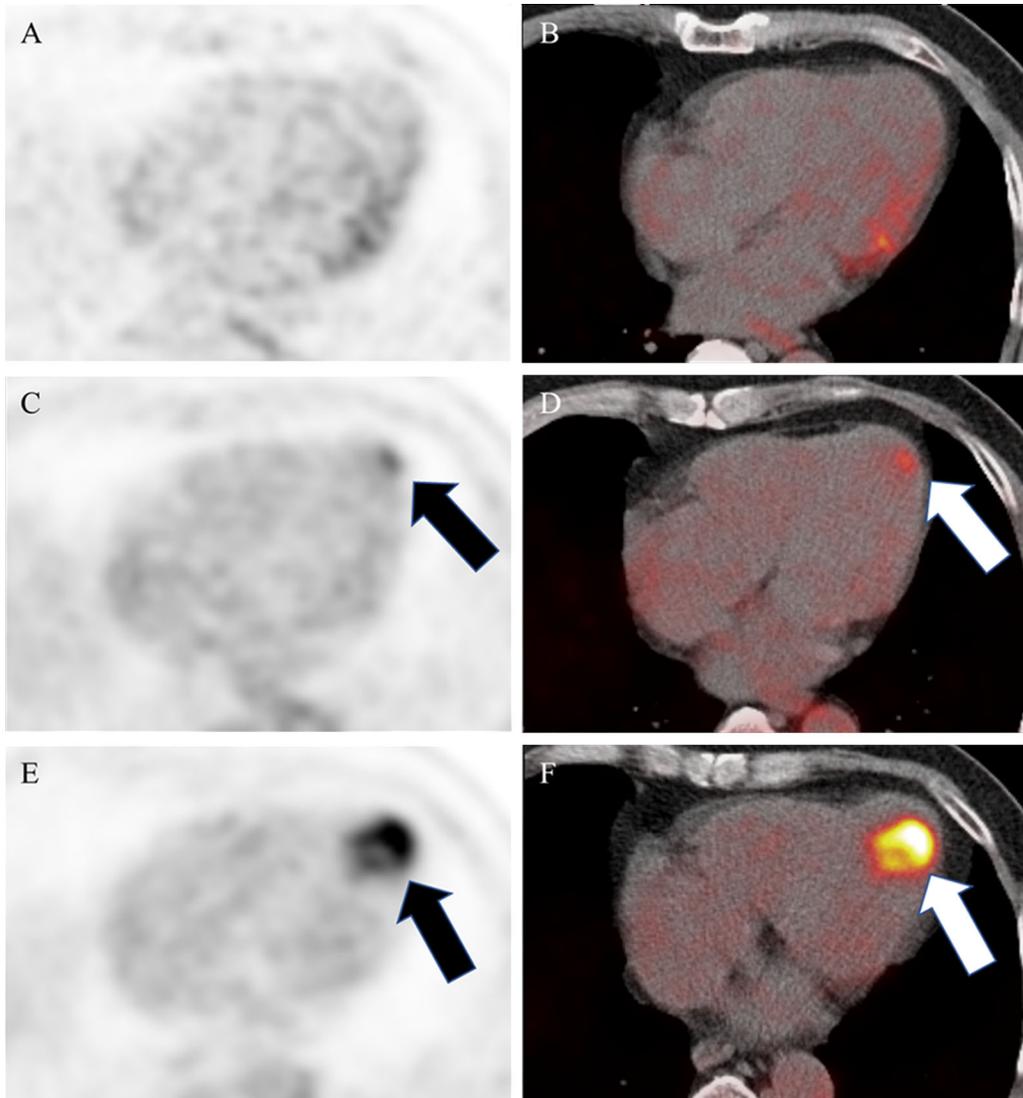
^{18}F -FDG PET and ^{18}F -FDG PET/CT images.
